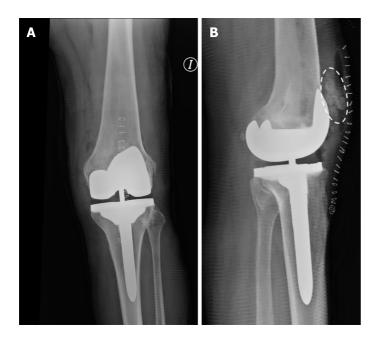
Immediate postoperative X-rays. A: It demonstrates good alignment of total knee arthroplasty in the anteroposterior view; B: In the lateral view, the neo-patella evidence is filled with bone chips (dashed circle), giving the appearance of a fragmented patella.
